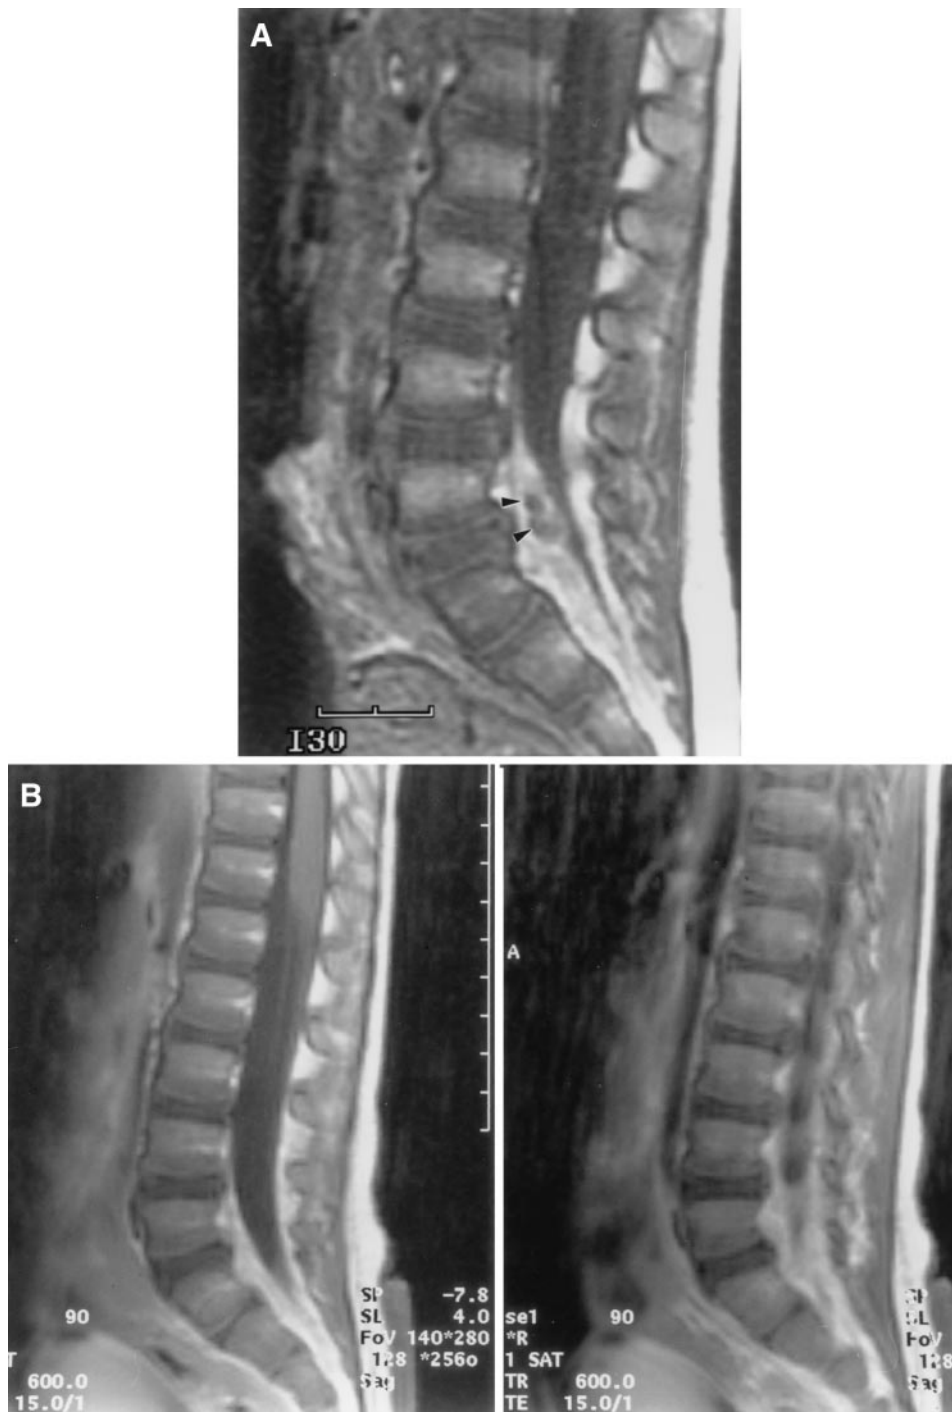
A, Sagittal T1-weighted MRI demonstrates a lesion anterior to the thecal sac behind the L5/S1 disk (black arrow heads) consistent with an epidural abscess. The lesion is isointense with cerebrospinal fluid and displaces the thecal sac posteriorly. B, The epidural abscess is no longer visible on 2 sagittal T1-weighted MRI images obtained 9 days after the initial examination.
